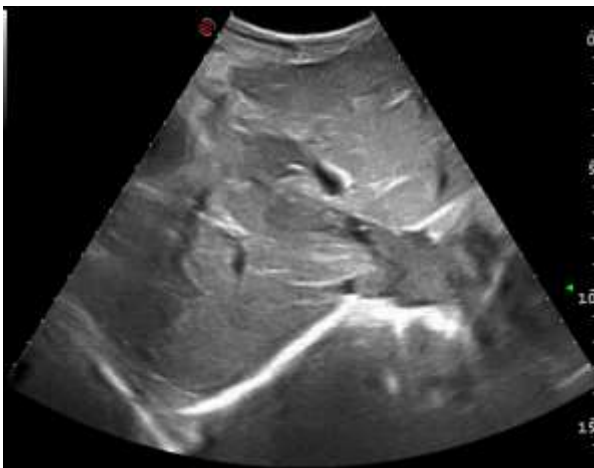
Ultrasonography image showing mass in right lobe of liver with IVC extension
